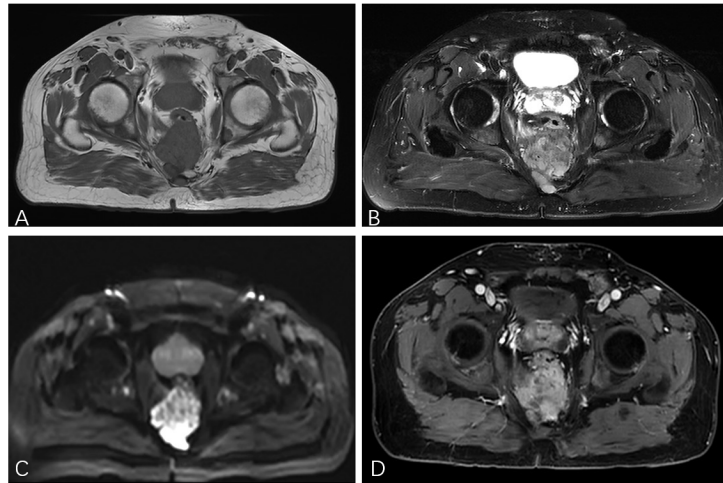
MR Images showed a 64 mm × 53 mm cystic and solid mass in the presacral region. (A) Axial T1-weighted MR Images showing a mass with hypointensity. (B) Axial fat-suppressed T2-weighted MR Images showing a mass with hyperintensity. (C) Diffusion-weighted images showing diffusion restriction. (D) Axial contrast-enhanced T1-weighted images showing significant enhancement.
